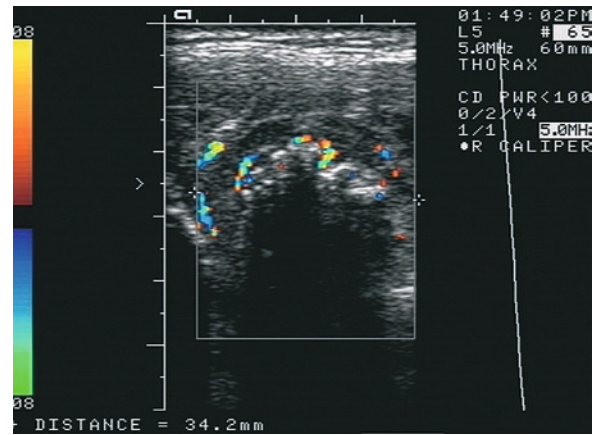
An 83-year-old man with a swelling that is tender to pressure in the left sternoclavicular joint. On sonography there is a hypervascularized tumor formation accompanied by elimination of the joint space and the cortical reflex. The primary tumor was an adenocarcinoma in the left upper lobe
